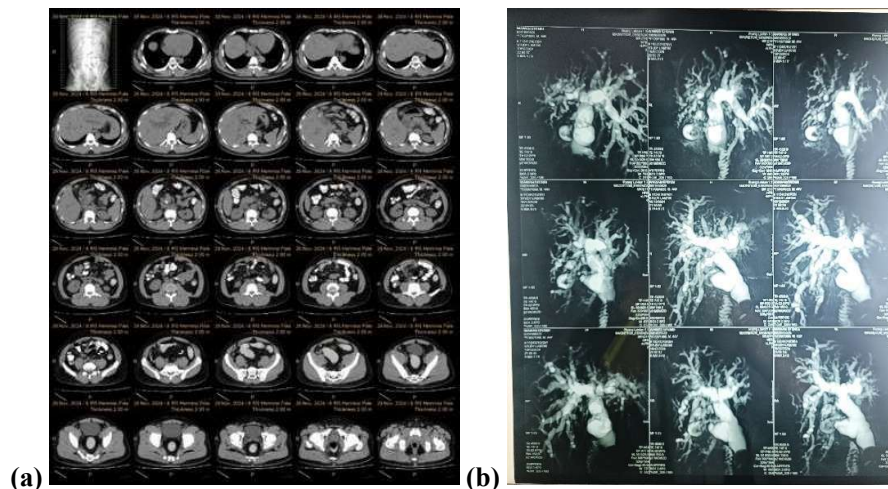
(A) CT Scan, (B) MRCP
